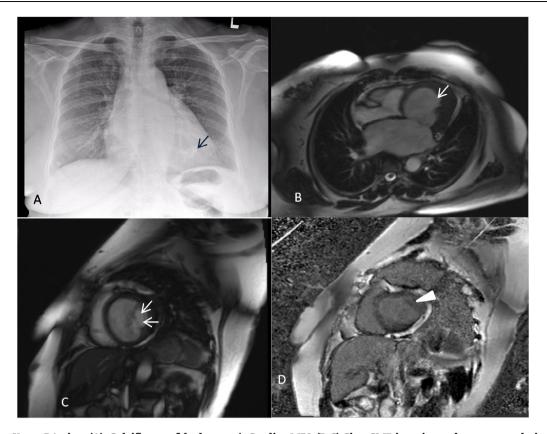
Chest X-ray PA view (A): Calcific spot (black arrow); Cardiac MRI: (B,C) Cine CMR imaging – shows normal-sized LV with obliteration of apex (white arrow in B) and calcified thrombus (double arrow in C). LA dilatation, and normal RA/RV noted. (D) Postcontrast imaging (PSIR sequences at 20 min) – shows subendocardial gadolinium enhancement (arrow head) of the same regions.
